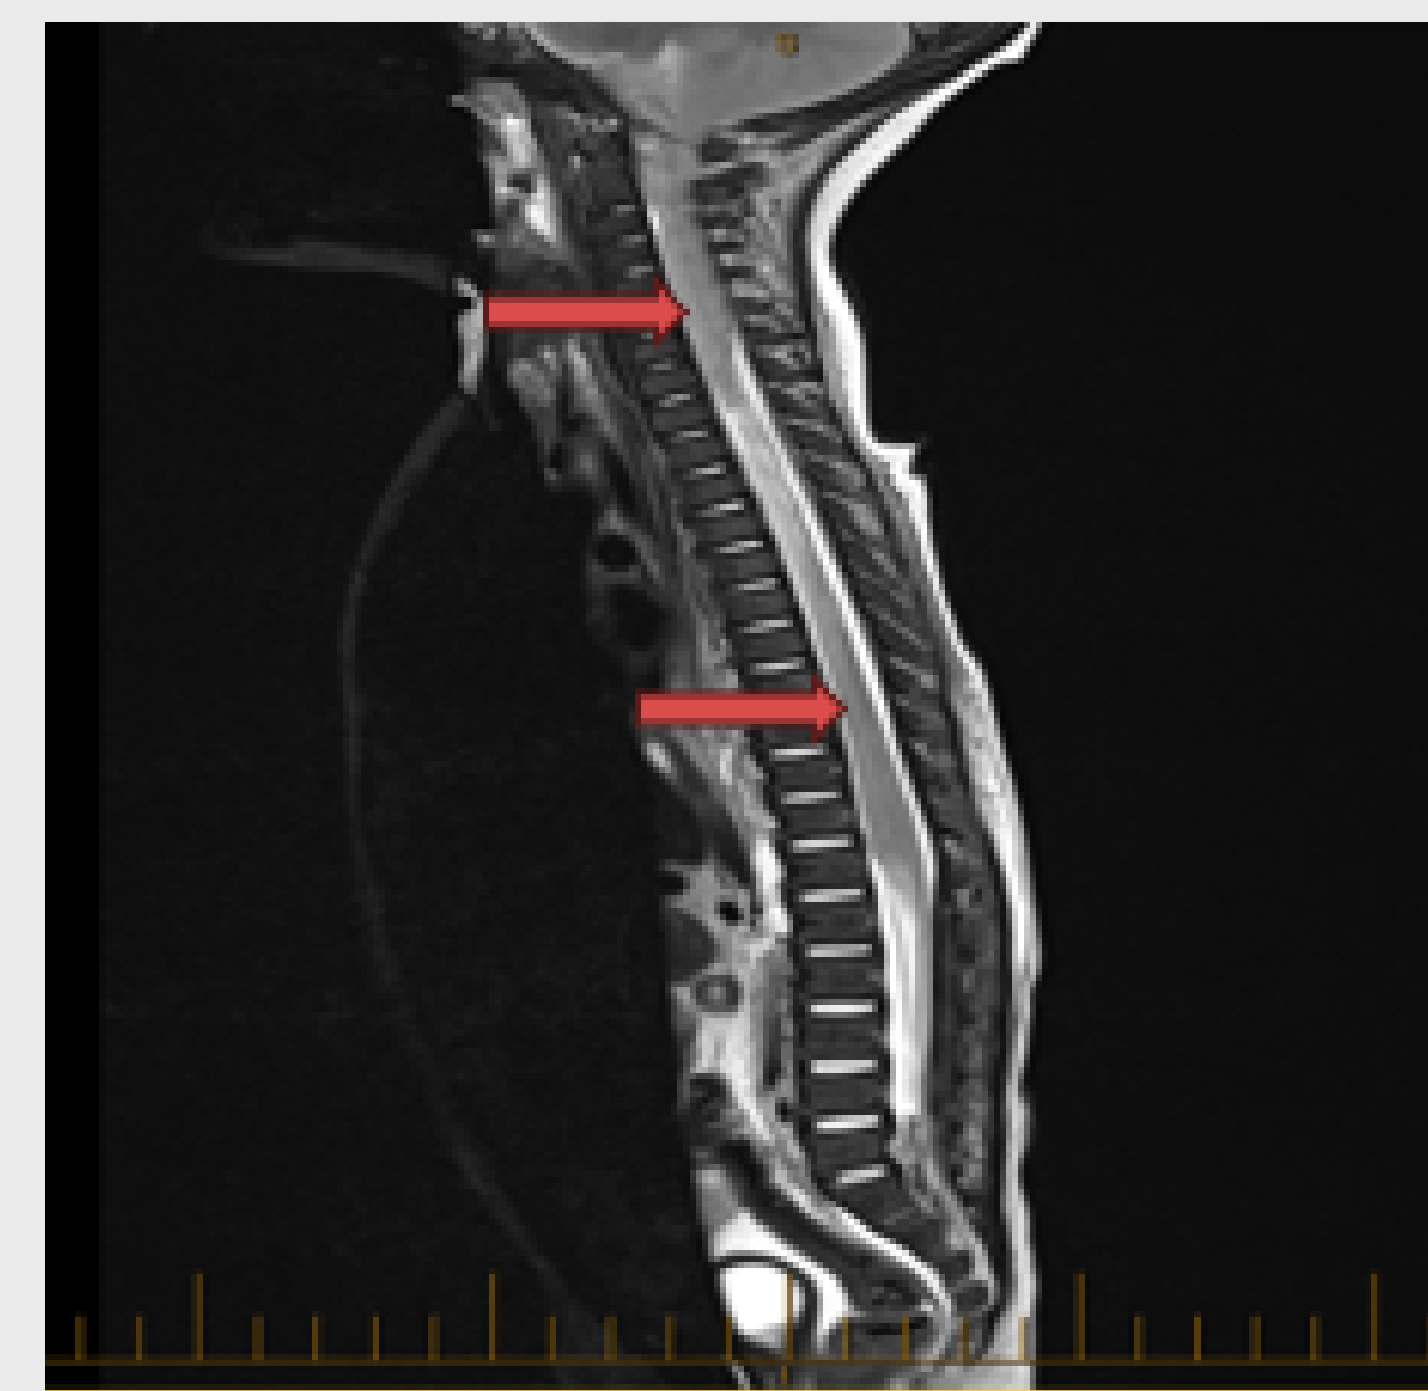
Case 1 – Spine MRI: There is diffuse spinal cord ischemic injury with enlargement of the cord related to swelling more pronounced at the cervical cord level, diffuse extensive restricted diffusion extending from the cervicomedullary junction to the distal tip of the conus medullaris, hyperintense T2 signal involving more the central grey matter than the white matter of the cord diffusely. No evidence of intramedullary bleed based on T1 and T2 mapping. There is an intracanal bleed on the caudal aspect of the thoracic sac showing dependent hyperintense T2, hyperintense T1 signal at the lumbosacral spine level from L1 level and below. There is no associated epidural or subdural bleed seen. There are no signs of spinal vertebral injury. The vertebrae are well aligned. There is no signs of disc or ligamentous injury.
